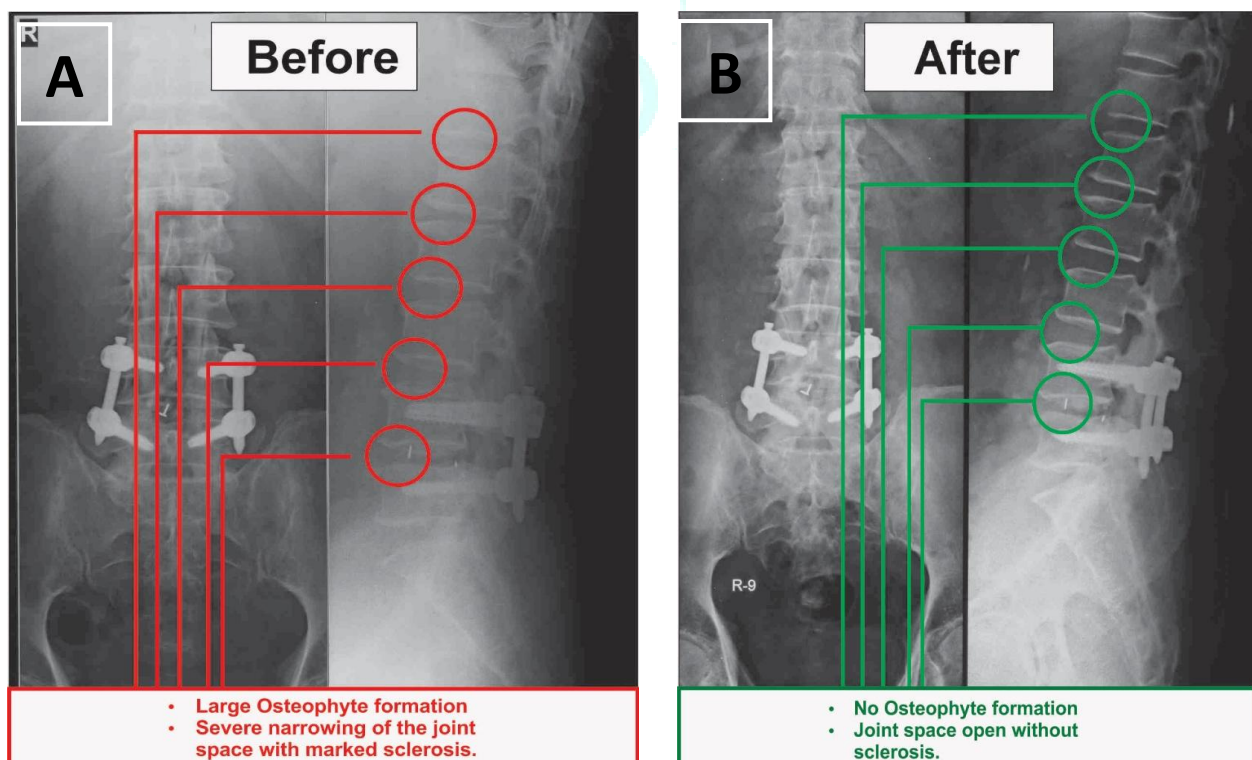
Radiographic images of before and after the treatment of lumbar spine
